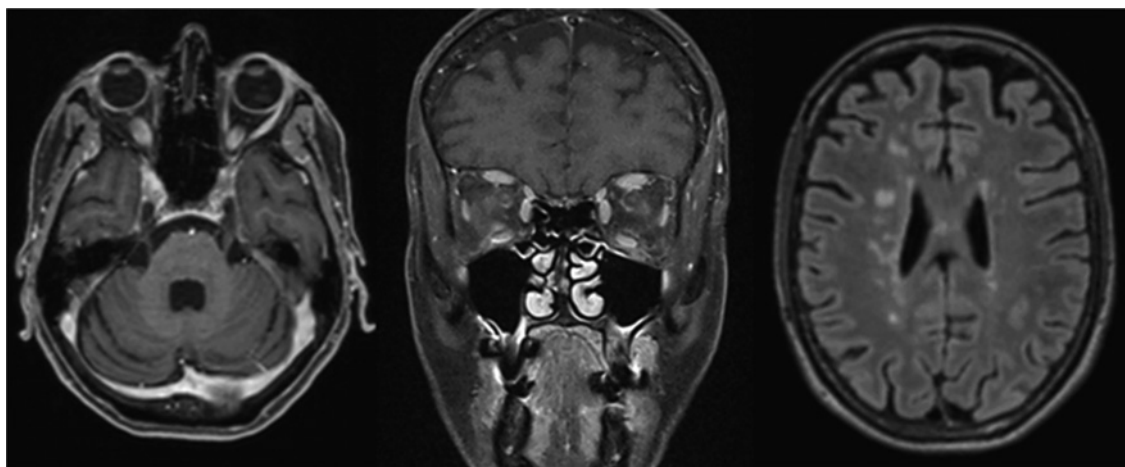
Three MRI T1-weighted images (axial, frontal, axial) showing bilateral prechiasmatic enhancement of the optic nerve, pronounced on the right side. Left optic nerve is smaller, possibly due to a post-inflammatory atrophy. Right image showing typical periventricular MS lesions.
